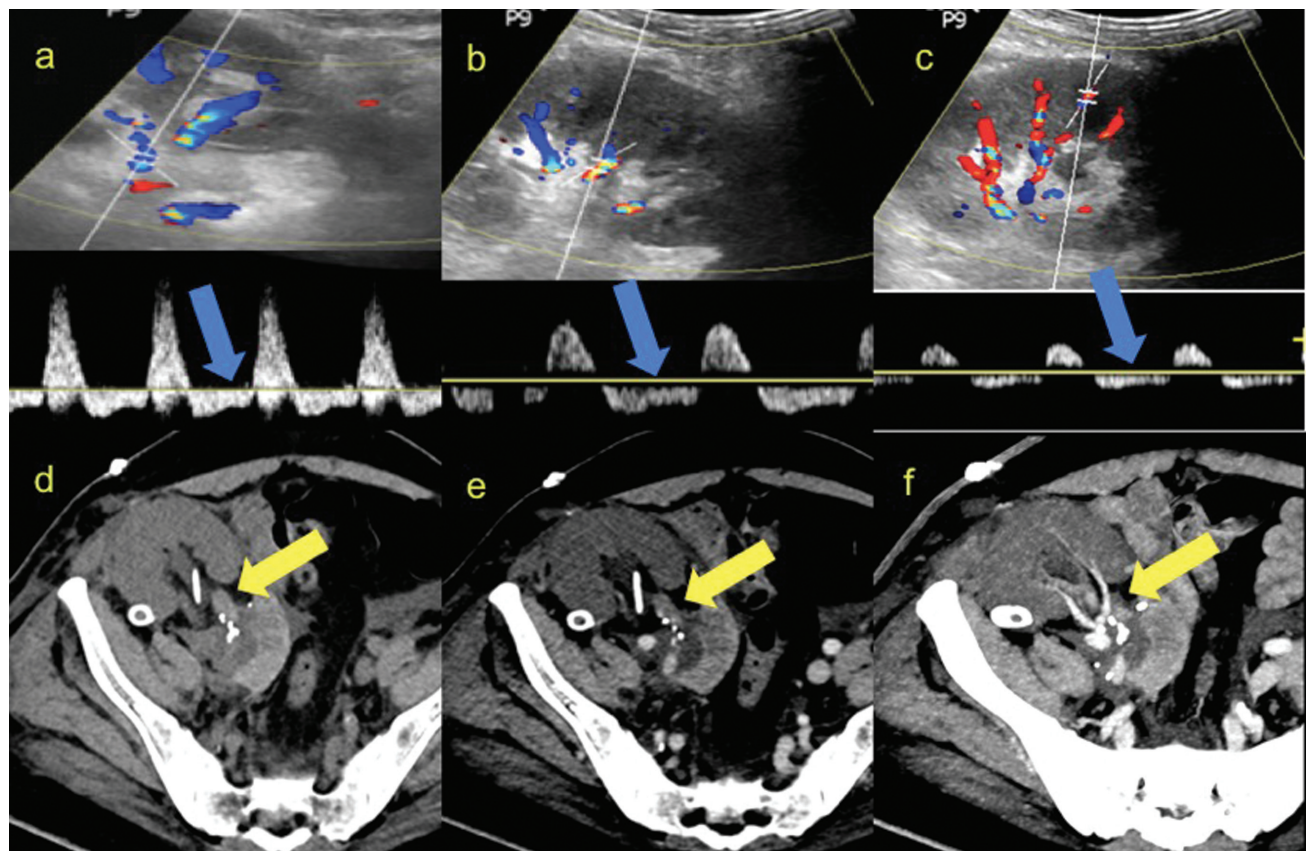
Spectral doppler images of main (a), segmental (b), and arcuate (c) renal arteries of the transplanted kidney show reversal of flow (blue arrows) in the diastolic phase. Noncontrast CT image (d) of the same patient in the axial plane shows a hyperdense main renal vein (MRV). Contrast-enhanced CT images in the axial plane (e) and maximum intensity projection (MIP) (f) show a filling defect (yellow arrows) in the main renal vein, consistent with MRV thrombosis. CT, computed tomography.
